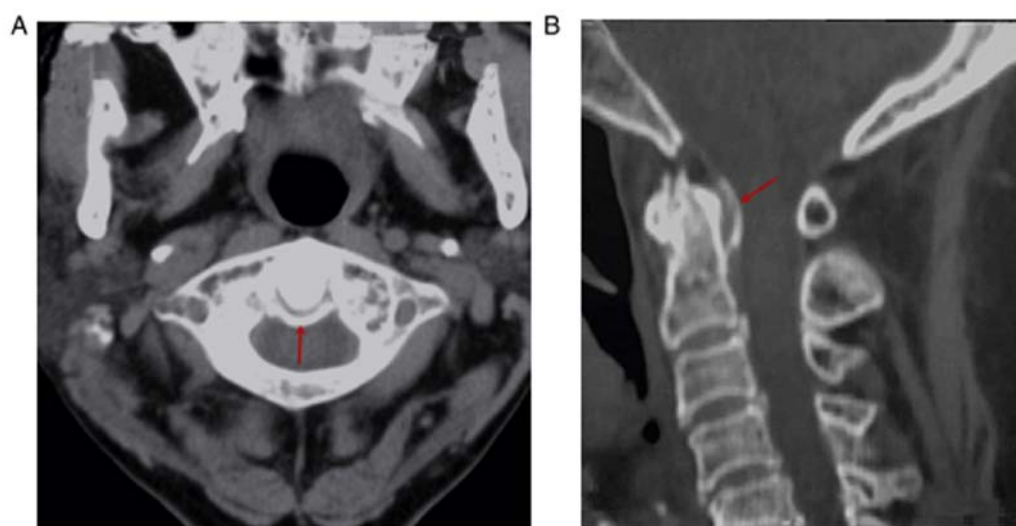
CT scans of a 78-year-old female. CT scans revealing (A) an arc-shaped calcification of the transverse ligament and (B) vertical line-like calcification of the cruciate ligament of the atlas in the posterior area of the odontoid process. Red arrows indicate the sites of calcium deposition.
